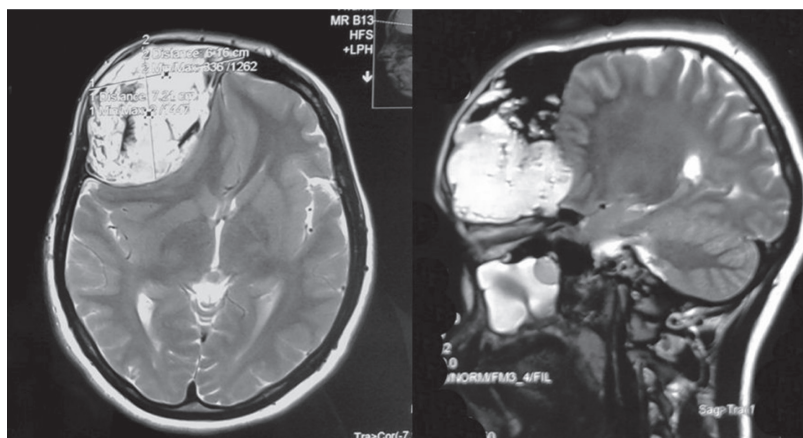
MR image showing a well-circumscribed, heterogeneous and fat-density mass involving the right frontal wall
